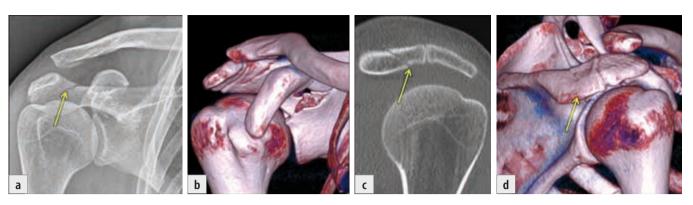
Fracture of the acromial angle associated with os acromiale: a) radiograph, the yellow arrow shows the fracture line in the acromial angle, the line of os acromiale cannot be well seen, while the fracture of the superior glenoid is clearly visible; b) 3D CT reconstruction, fracture line and the line of os acromiale are clearly visible; c) 2D CT reconstruction, the two lines can be well seen; d) 3D CT reconstruction, posterior view, the fracture line indicated by the yellow arrow is almost invisible.
